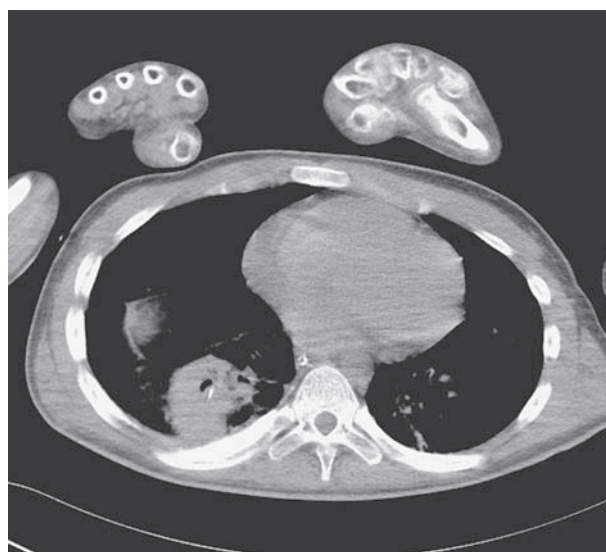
CT of chest revealed a retained metal wire with abscesses formed over the right lower lobe of the lung.
